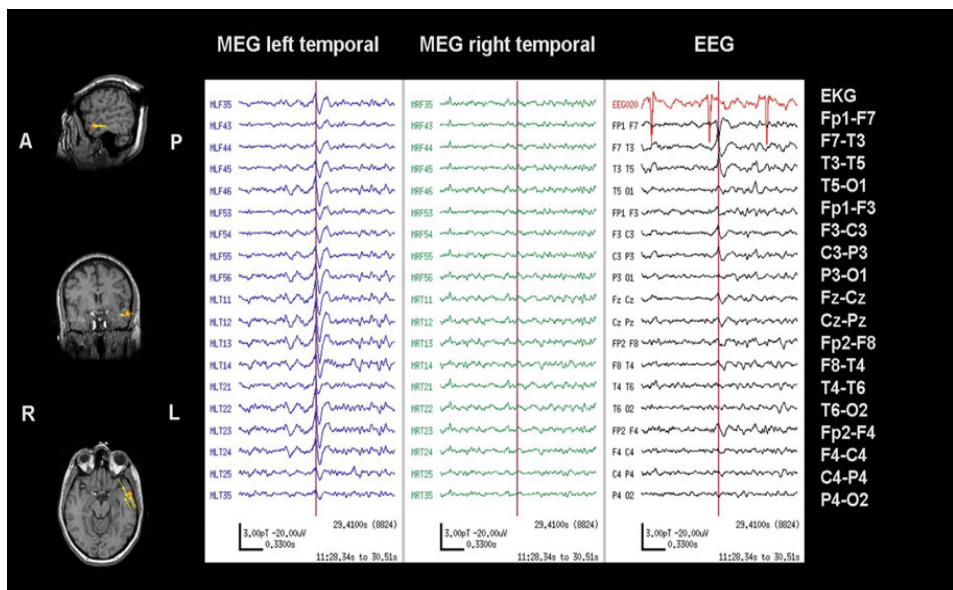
MSI and MEG with simultaneous scalp EEG showing interictal unilateral temporal spikes. Single dipole source models are shown as yellow triangles with vector tails proportional to dipole strength, superimposed on the anatomical MRI. MEG and EEG show a representative left temporal spike marked with a vertical cursors. The corresponding dipole is outlined in orange on the MSI
